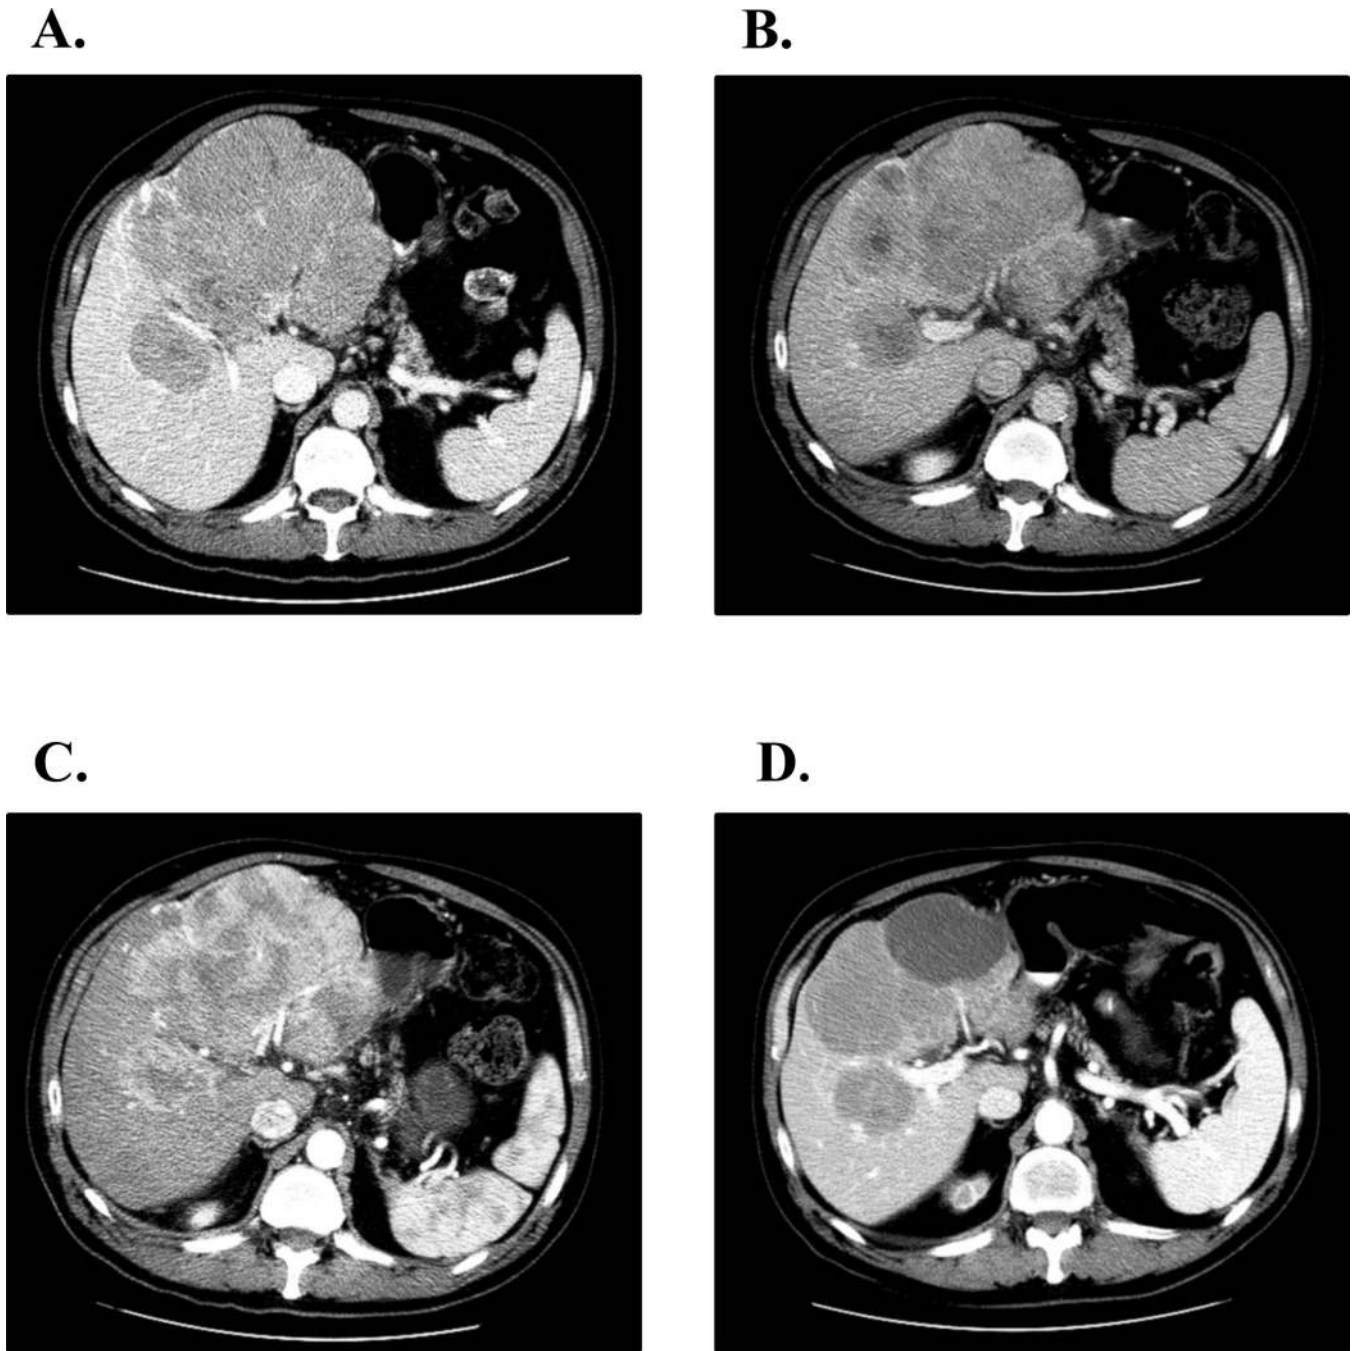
Response of liver metastases to treatment (WLRT dose of 32 Gy/2 Gy fractions). Computed tomography images before the treatment (A), 2 months after the first part of the treatment (B), 2 months after the second part of the treatment (C), and 24 months after the second part of the treatment.
